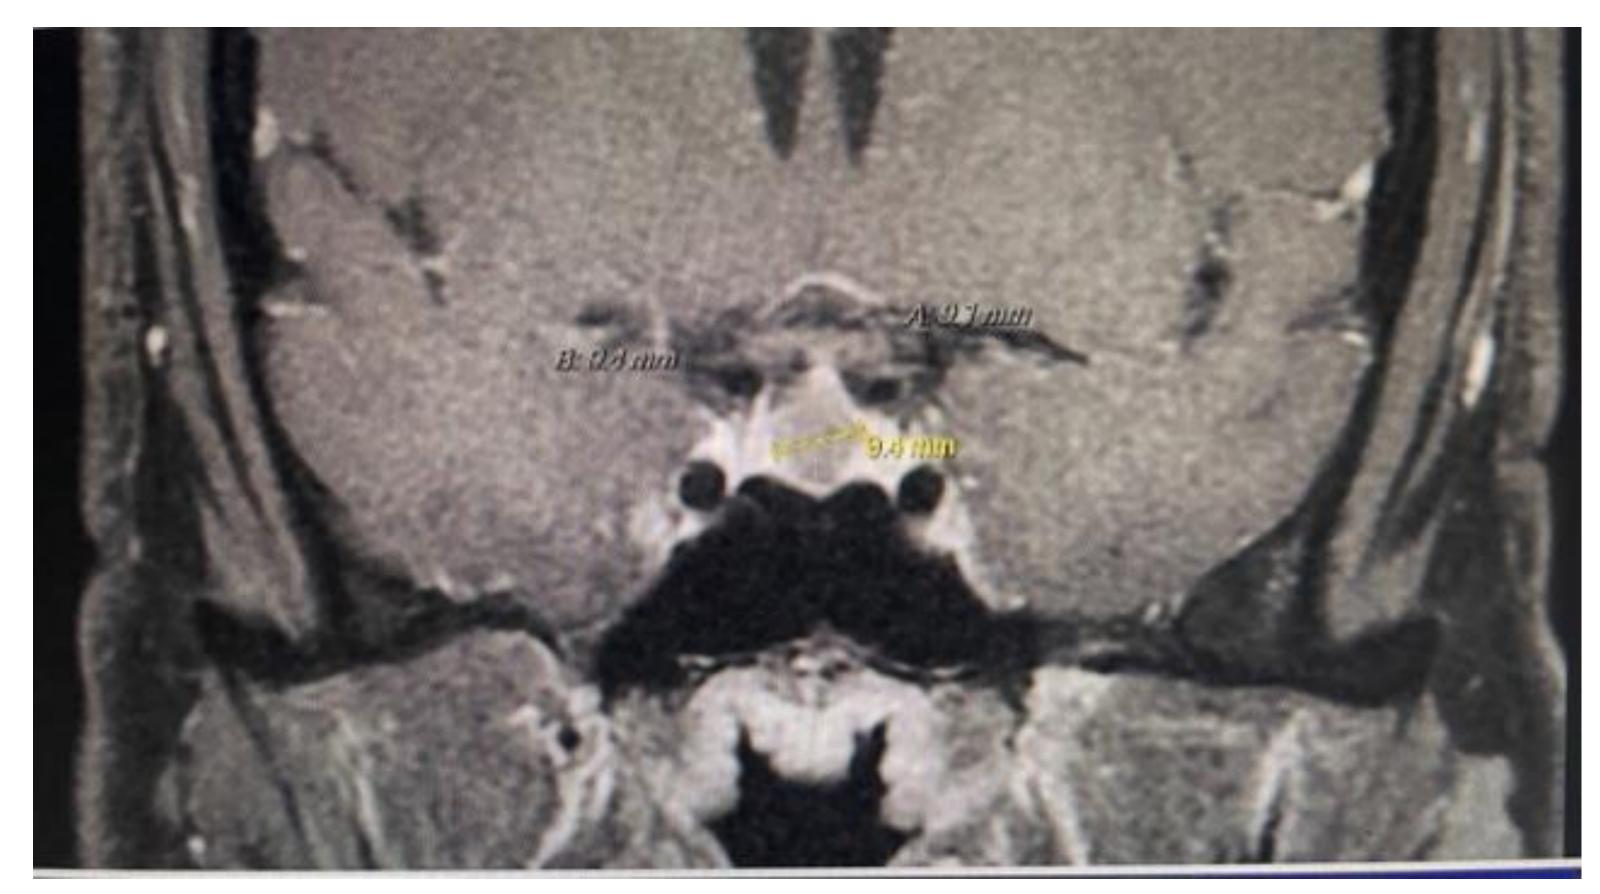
MRI shows Pituitary adenoma measuring 9.4mm
